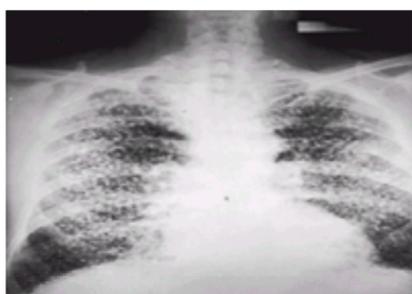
Chest radiograph of a subject with stannosis. Tin oxide, having a high atomic number, shows up as intensely radiopaque deposits.
